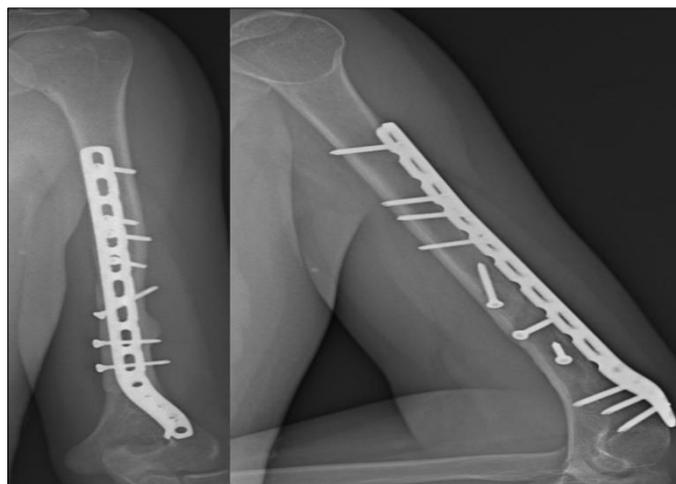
Postoperative radiograph at 4 weeks of follow up
